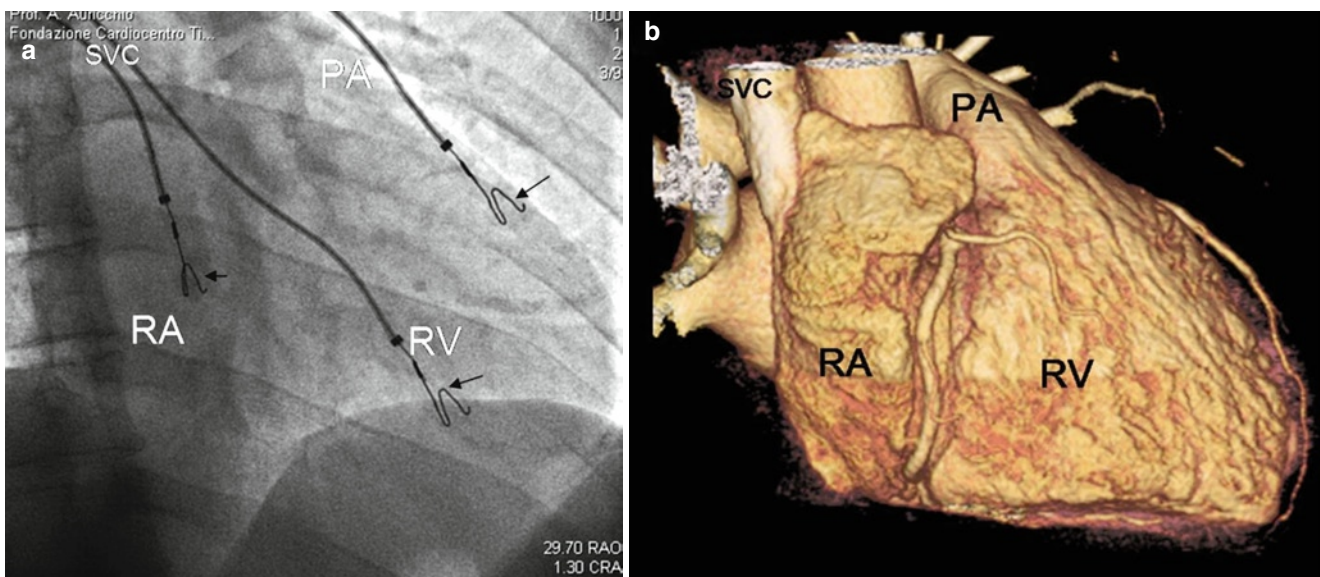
(a) Fluoroscopic image in right anterior oblique projection and (b) the corresponding 3D CT volume rendering. *RA* Right atrium, *RV* right ventricle, *PA* pulmonary artery, *SVC* superior vena cava.
